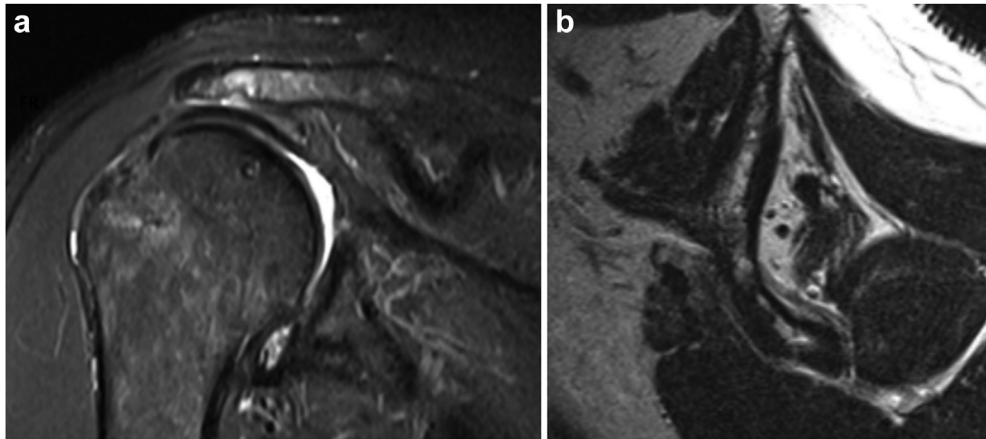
(a) Postoperative coronal and (b) sagittal T2 MRI at two years showing intact graft and Goutallier stage II/III supraspinatus. MRI, magnetic resonance imaging.
